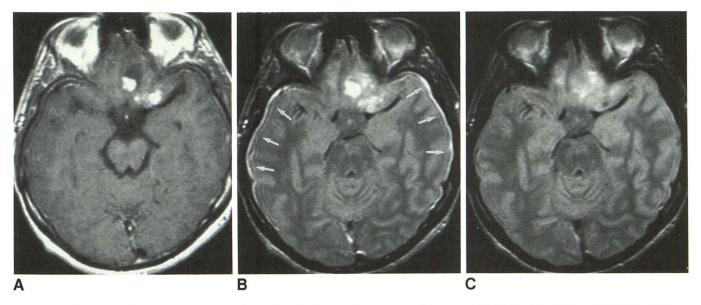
A-C, Lesion enhancement in patient with recurrent astrocytoma is demonstrated on postcontrast T1-weighted image (A) and postcontrast spin-density-weighted image (B). In addition, postcontrast spin-density-weighted image shows a new finding of bilateral dural enhancement (arrows) as compared with precontrast spin-density-weighted image (C). Finding was not apparent on A, and is most likely the result of delayed enhancement of the dura
